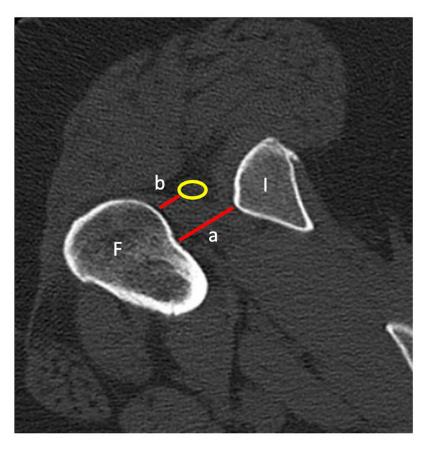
Axial CT showing ischiofemoral distance (a) between the medial part of the femoral neck (F) and ischium (I) and distance between the sciatic nerve (yellow ring) and medial part of the femoral neck (distance b).
